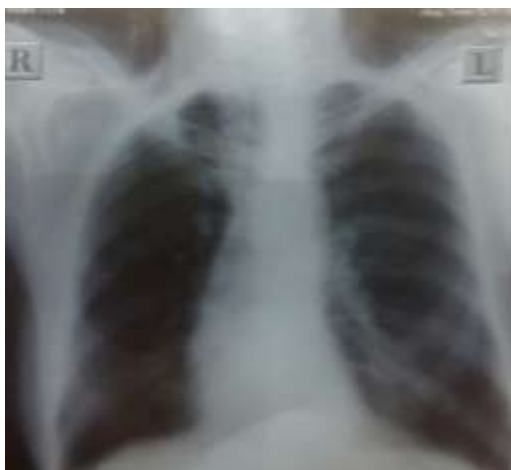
X-ray chest showed right sided hyper-lucent lung
